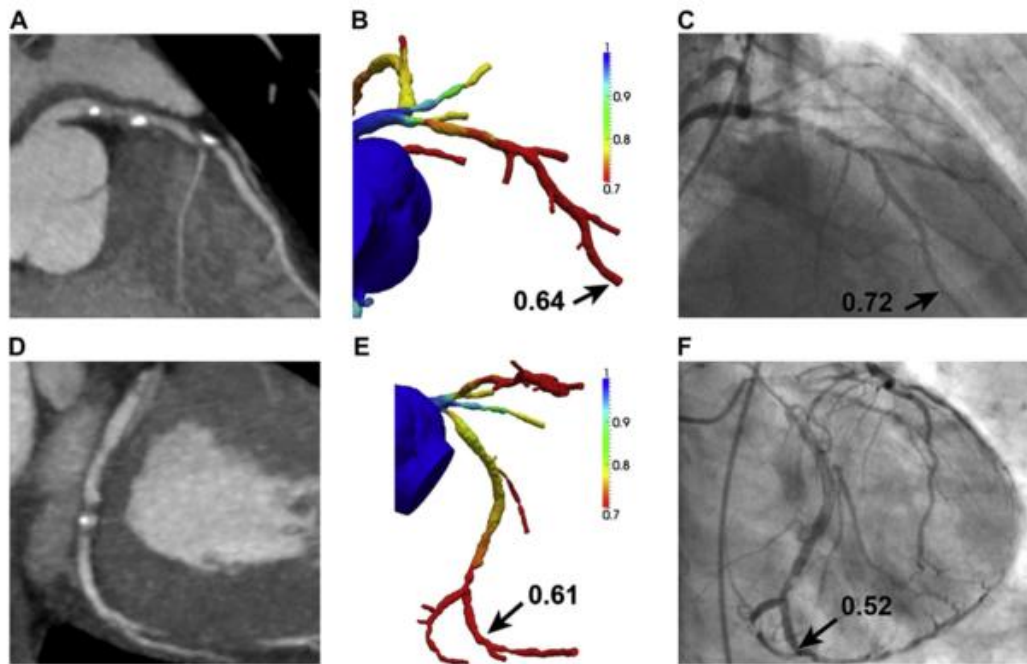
(A) CTA image showing a stenosis in LAD, (B) FFR_{CTA} estimates FFR value as 0.64, (C) True FFR value is measured as 0.72, (D) CTA image showing a stenosis in LCX, (E) FFR_{CTA} estimates FFR value as 0.61, (F) True FFR value is measured as 0.52 [46].
